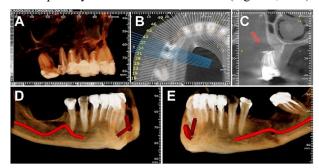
CBCT scan: (A) Lateral view upper right quadrant; (B) Axial view of the upper right quadrant; (C) 24-section showing an important bony defect after apicectomy; (D) Right and (E) left important mandibular bone resorption. CBCT: Cone-beam computed tomography.
